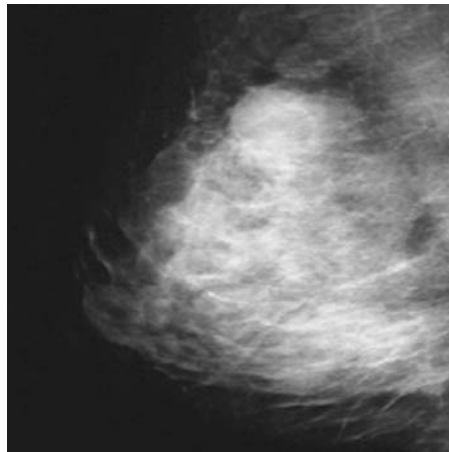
X-ray image of breast cancer.
